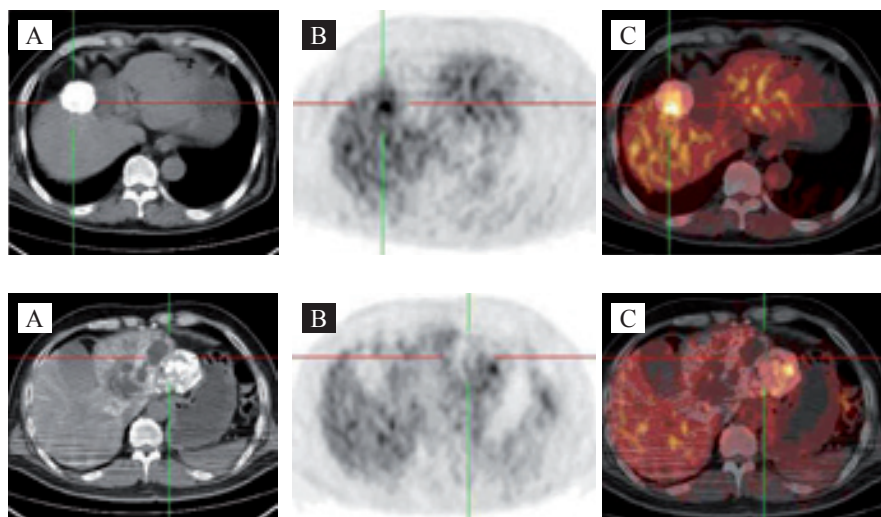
A 58 years old woman with HCC treated with TACE. Interval from TACE to PET was 78 days. Serum AFP concentration was 210.8ng/mL. The patient underwent PET-CT for clinically suspected recurrence. Multiphasic CT (A) shows wide lipiodol dense distribution in the right lobe of the liver, ^{18}F -FDG PET-CT images (B and C) show increased activity in the marginal portion of the tumor.
